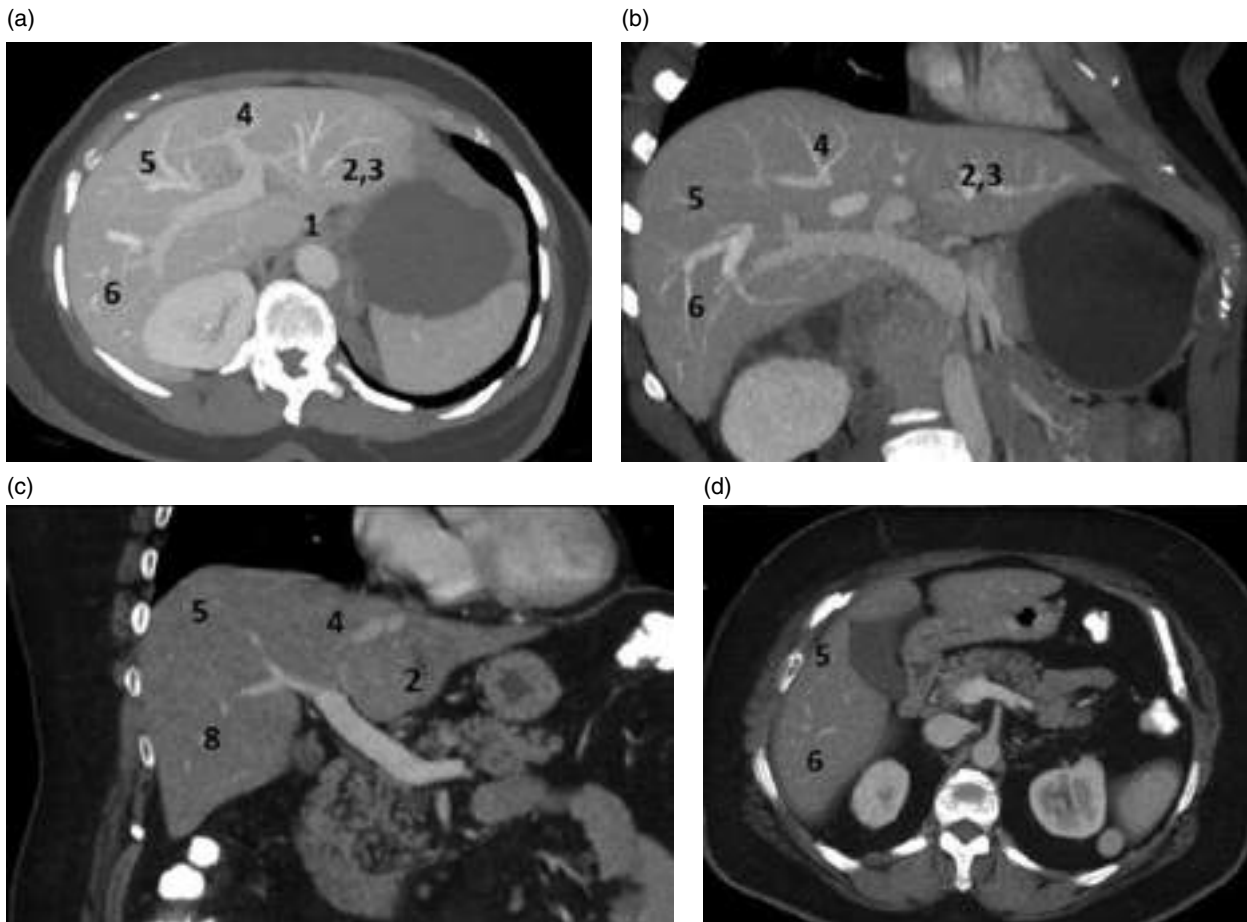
Segments of the liver and relations with the portal vein. (a, d) Axial contrast-enhanced CT image (portal venous phase). (b, c) Coronal contrast-enhanced MPR CT image (portal venous phase).
